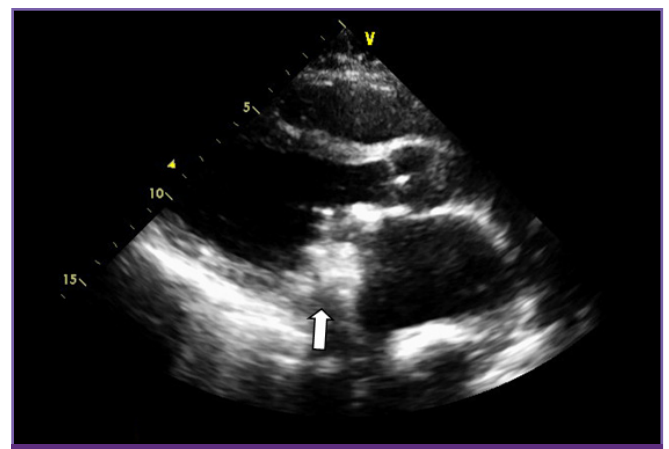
Transthoracic echocardiography showing thrombus and vegetations (white arrow) on the mitral prosthetic valve diagnostic of endocarditis.
